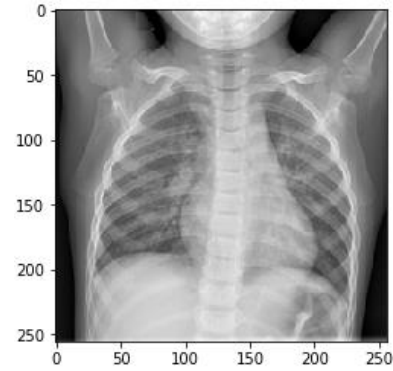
A sample chest x-ray image in the data set (“Chest X-Ray Images”, 2019).
